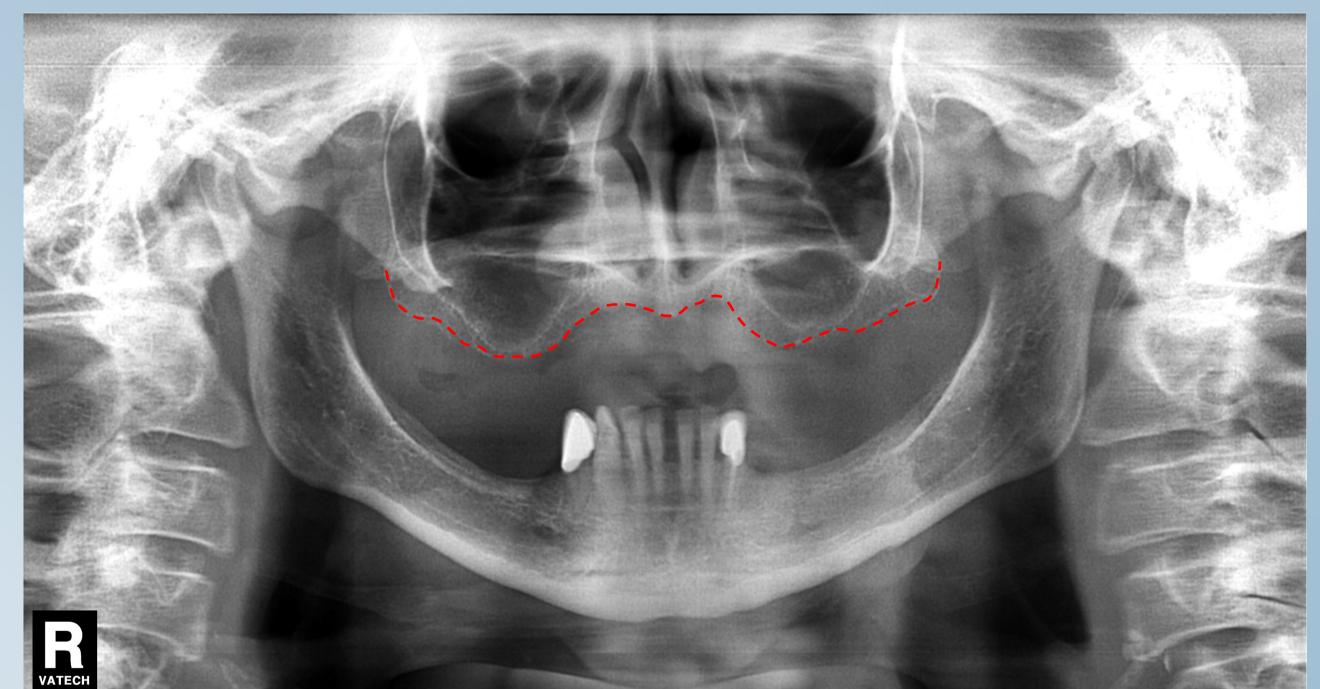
Panoramic X-ray of the patient (alveolar ridge contour highlighted)
